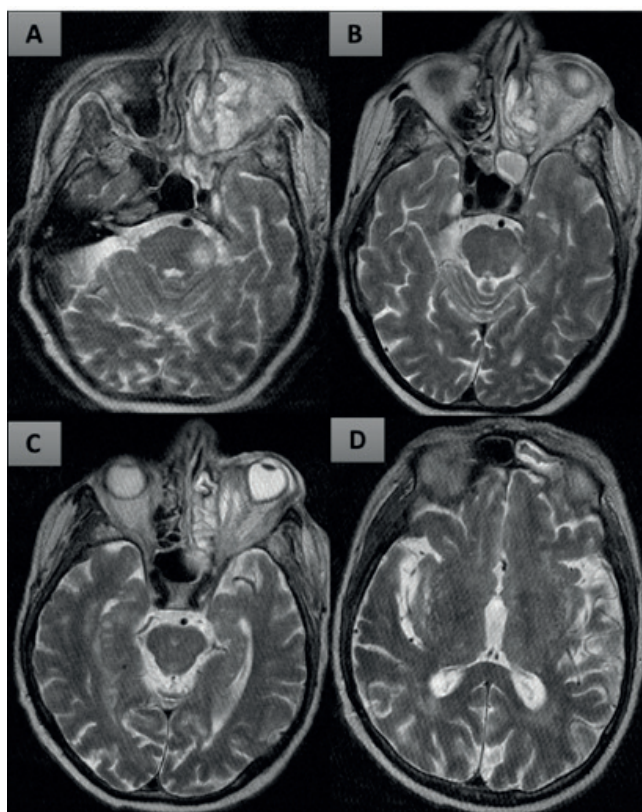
Magnetic resonance images of the patient: As a result of mucormycosis; increased density in the left maxillary sinus, deviation of the nasal septum (A), increased density in area of the left parasphenoid and medial paraorbital (B), increased density in the left ethmoid sinus and exophthalmos in the left orbit (C), increased density in the left frontal sinus (D).
